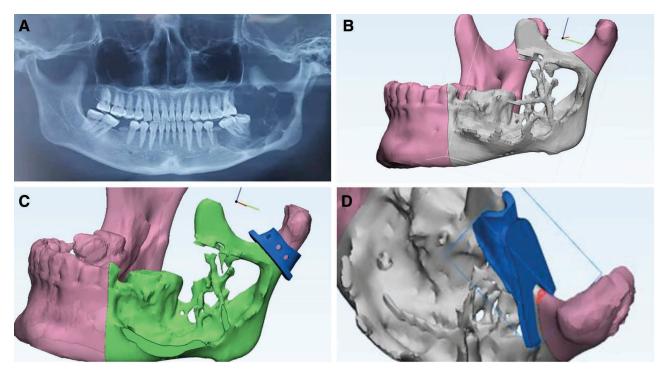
Virtual surgical planning for tumor resection and bone reconstruction. A, A preoperative panoramic radiograph showing a sizeable multilocular lesion on the left side, with molars and mandibular ramus invaded. B, Planned osteotomy lines for tumor resection. C, Traditional osteotomy guide plate designed based on the extraoral incision, showing that the plate was positioned through the subcondyle area from the buccal side. D, Modified virtual osteotomy guide plate, designed according to the characteristics of the intraoral approach and endoscopic field; the sigmoid notch was chosen for retention.
